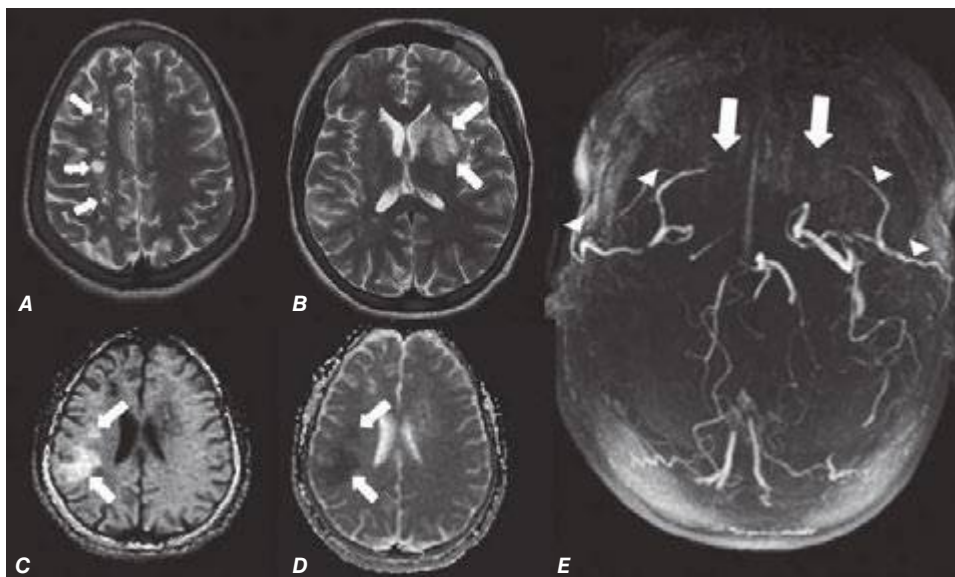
57 Sickle cell disease and moyamoya disease (Chap. 446). Axial T2-weighted MRI (A, B) shows multiple small areas of encephalomalacia from prior infarcts in the watershed zones between the anterior and middle cerebral artery territories (*small arrows*). There is also an area of edema involving the left basal ganglia from an evolving subacute infarct (*arrow*). An axial diffusion-weighted image (C) with corresponding ADC map (D) shows an area of restricted diffusion in the right frontoparietal region, consistent with an acute infarct (*arrows*). Time-of-flight MR angiography (E) shows absence of flow in the distal internal carotid arteries and proximal middle cerebral arteries (*arrows*) due to moyamoya disease. Also note that this patient is status post–bilateral encephalo-duro-arterio-synangiosis (EDAS) (*arrowheads*), a surgical procedure to create indirect anastomosis between branches of the external carotid artery with distal branches of the middle cerebral artery.
